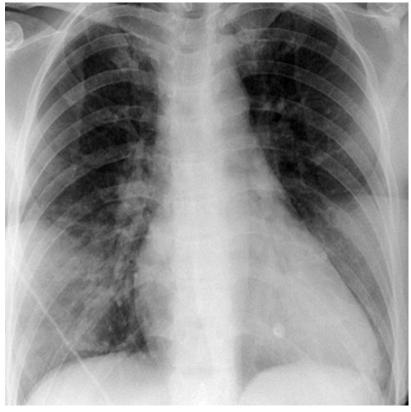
Chest x-ray (anteroposteror) showing pulmonary oedema.
